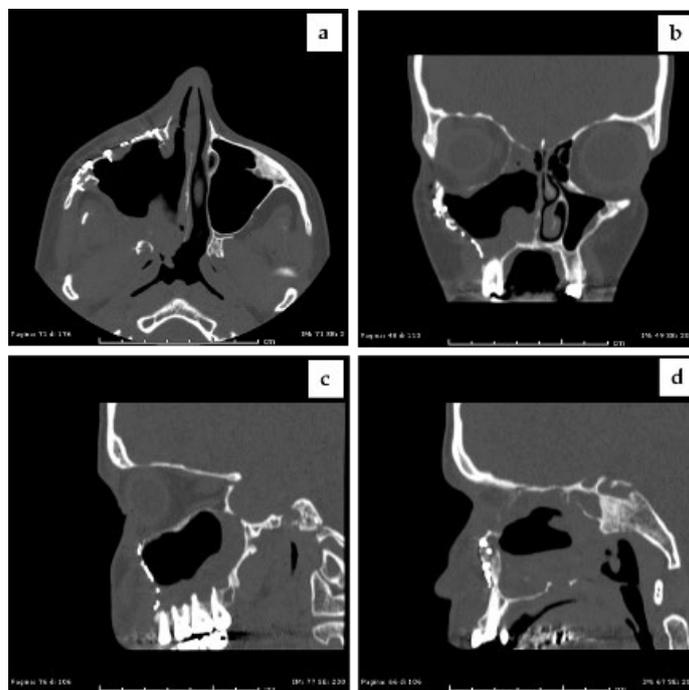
Post-operative CT. (a) Axial view; (b) coronal view; and (c,d) sagittal views.
